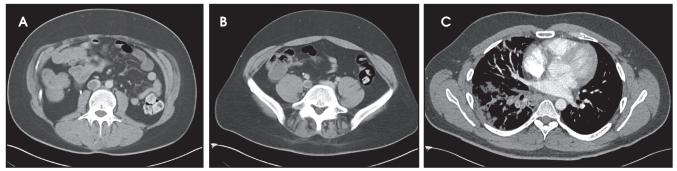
A 31-year-old man with acute pleuritic chest pain, dyspnea, and tachycardia following recent mid-lumbar laminectomy and fusion. Combined CT venography and pulmonary angiography demonstrated inferior vena cava and right iliac venous thrombosis, as well as right pulmonary emboli and associated infarctions, but no lower extremity DVT. (A) Transverse CT venography (CTV) image shows thrombus filling most of the lumen of the inferior vena cava (arrow). (B) Transverse CTV image demonstrates thrombus in the right common iliac vein, which is contiguous with the caval thrombus. (C) Transverse CT pulmonary angiography image shows emboli in two right lower lobe segmental arterial branches, as well as multiple areas of peripheral pulmonary infarction.
